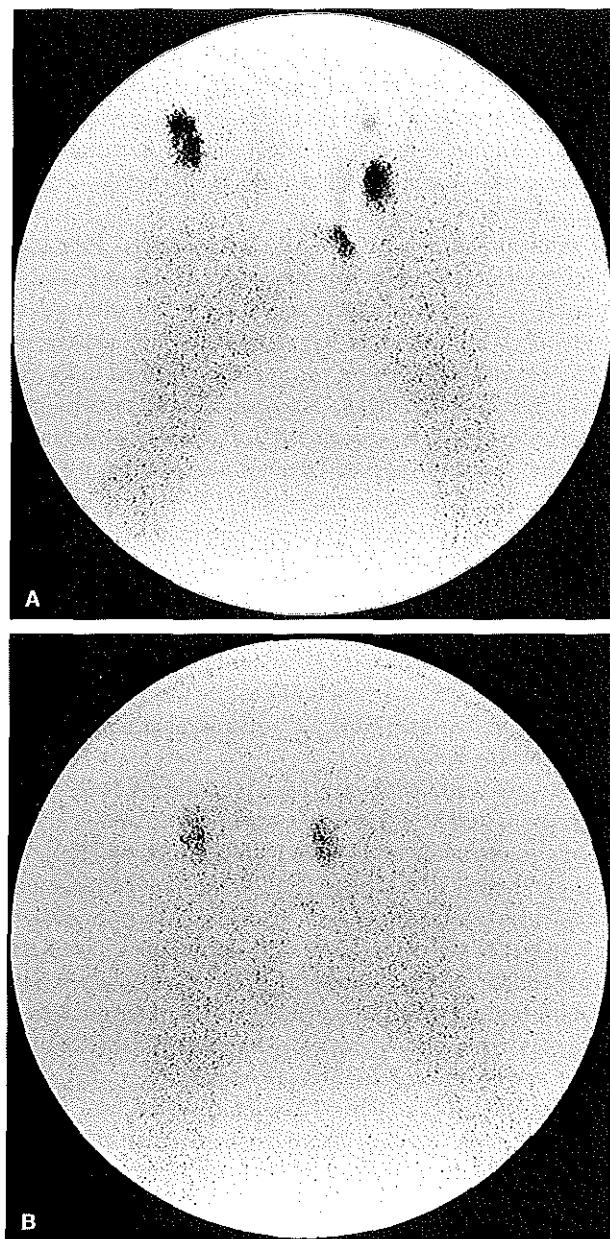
In vivo* somatostatin receptor scintigraphy (Octreoscan) of skin nodules of a sarcoidosis patient (patient 3). A. Uptake of radiolabel before the start of octreotide treatment. B. Uptake of radiolabel is greatly reduced after 3 months of treatment with octreotide. Scintigraphy was performed 2 weeks after cessation of octreotide treatment.
